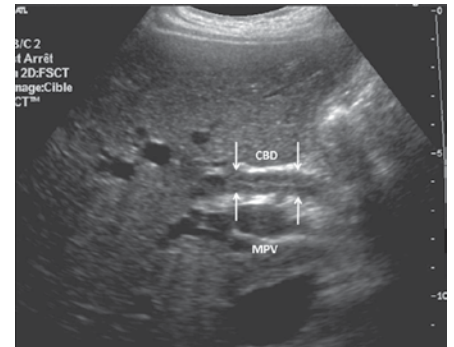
IgG4-related sclerosing cholangitis: Ultrasound showing circumferential thickening (arrows) of the common bile duct (CBD). (MPV = main portal vein).
